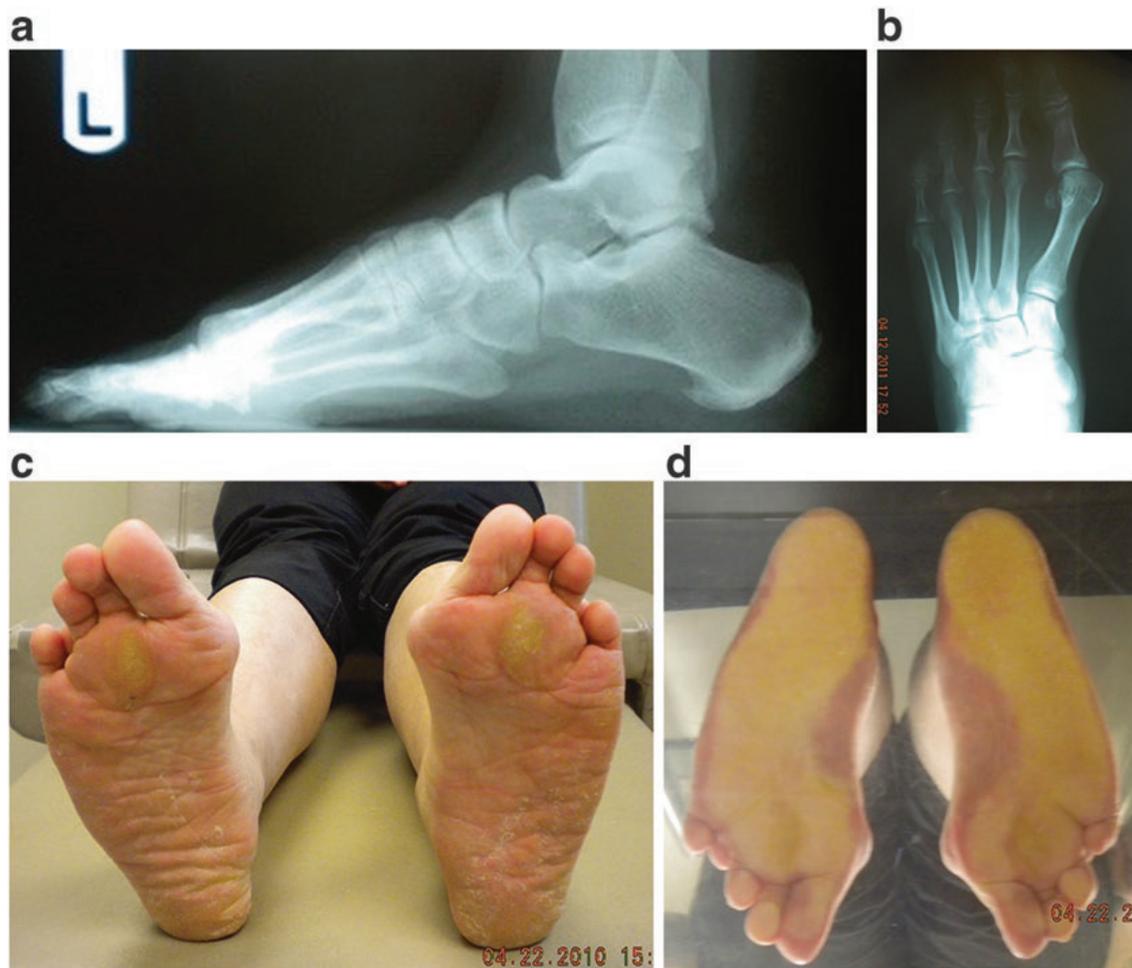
(a) A lateral radiograph projection demonstrating a patient who suffers from TMT-1 hypermobility/instability. Note the dorsal cortex of the first metatarsal in comparison to the second metatarsal leading to an elevated first metatarsal. (b) An appearance of a “long first metatarsal” on a AP radiograph secondary to the hypermobility. (c) Patient who presents with a HAV deformity bilaterally as well as a sub two callus lesion on both feet.
